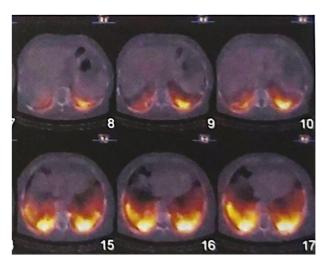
Perfusion scintigraphy revealing in left lung a sub-segmental hypo perfusion zone.
